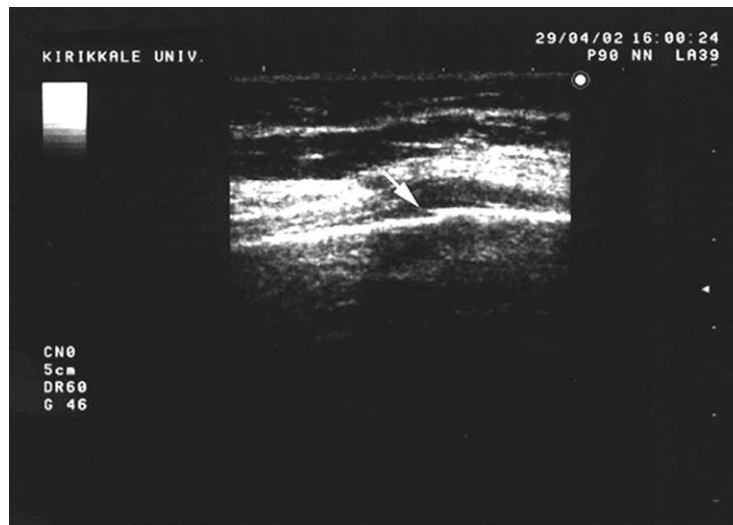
Transverse sonogram of a 85-year-old woman with bony fracture of right eighth rib which reveals an undisplaced rib fracture (arrow) and a hypoechoic area consistent with a subperiosteal hematoma above the fracture line.
